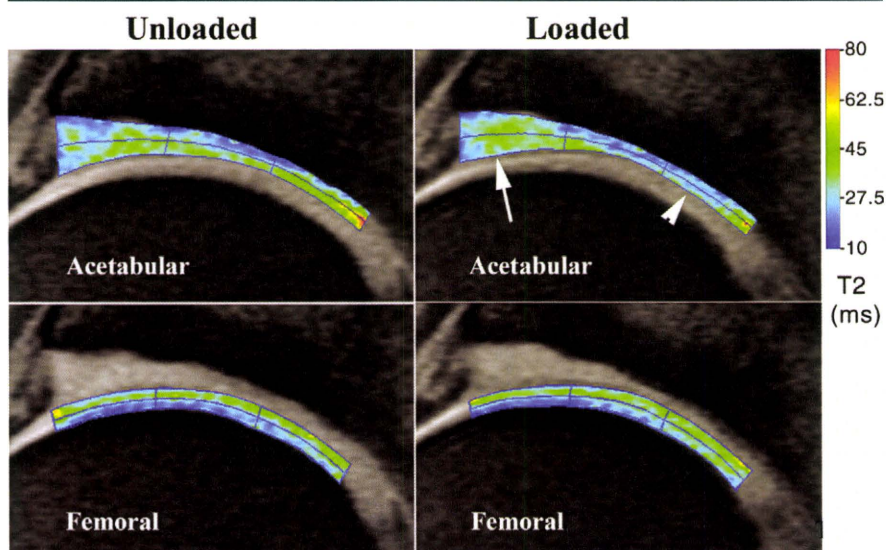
T2 maps of the acetabular and femoral cartilage on midcoronal MR images in a 30-year-old female volunteer. A low T2 is indicated by blue, and a high T2 is indicated by green or red. Under the loaded condition, the T2 of the acetabular cartilage was increased at the outer zones (Z1s and Z1d, arrow) and decreased at the inner, superficial zone (Z3s, arrowhead).
